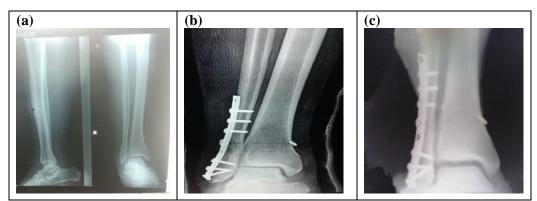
A case of 42 years old patient came to ER after motorcycle accident. (a) preoperative x-ray showing lateral malleolus injury with syndesmotic injury, (b) post-operative AP x-ray done 6 weeks after surgery with plate and screws and syndesmosis suture button fixing, (c) 6 month follow-up demonstrating healed Lat, malleolus damage, and syndesmosis suture button fixing.
